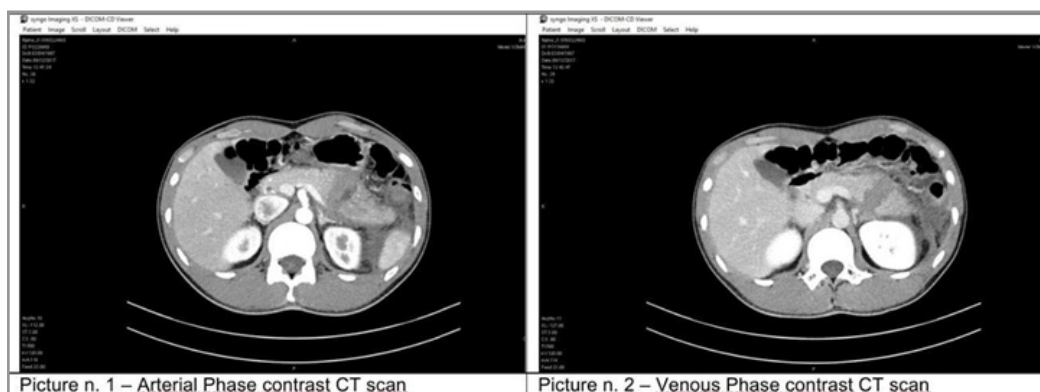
CT scan Shows a Pancreatic Involvement in a Handlebar Abdominal Injury.
